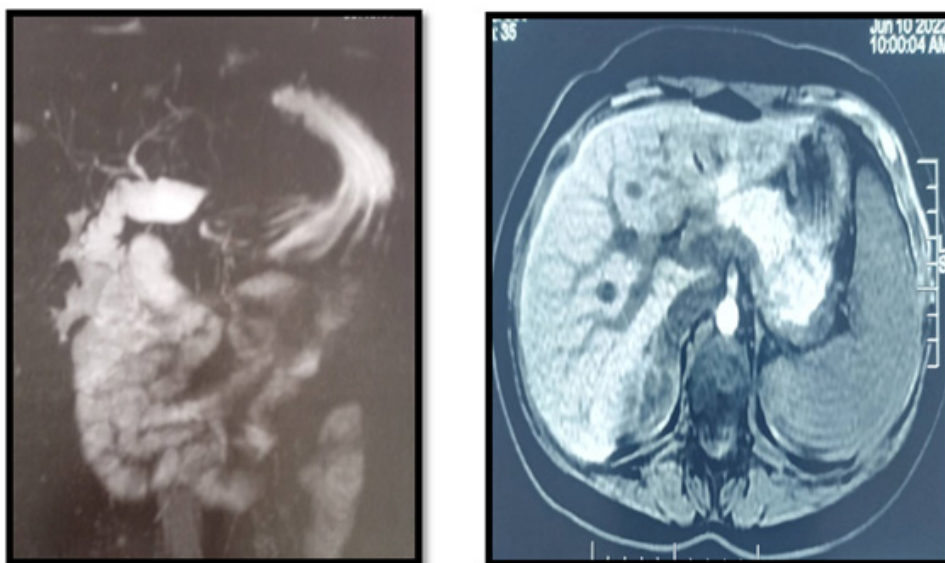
MRI photo showing missing gallbladder.
